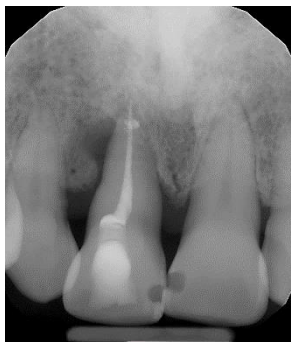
Periapical radiograph, after root canal therapy.
